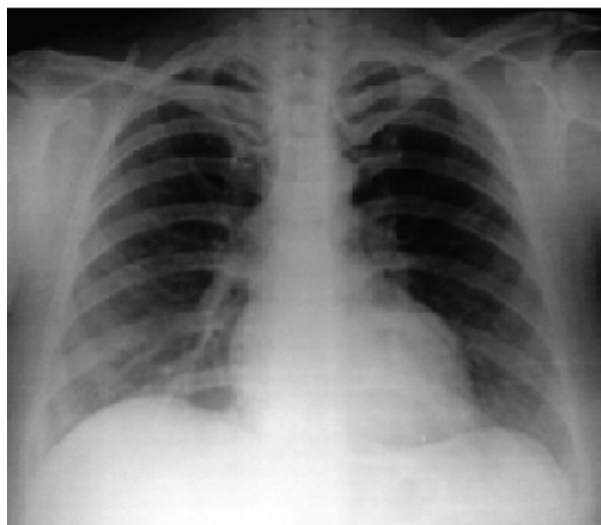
Chest radiograph on discharge
